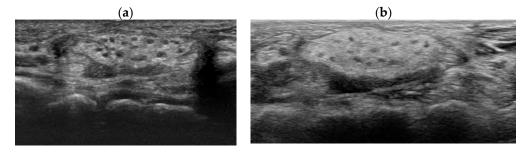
Ultrasonographic follow-up of left wrist at the postoperative (a) 5th and (b) 10th years.
